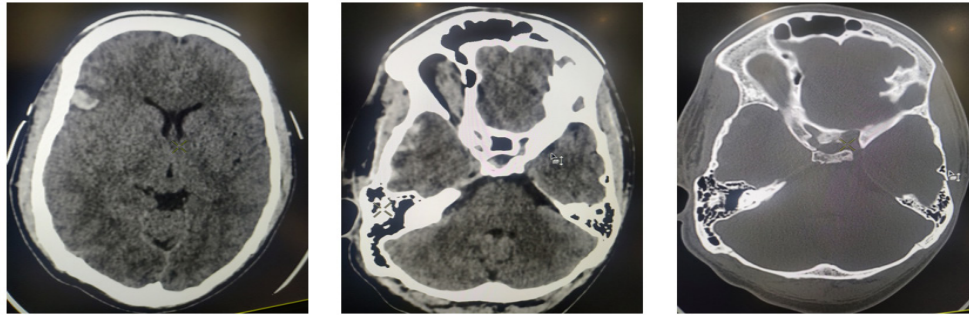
CT scan (Head) at Day 0: Right fronto-temporal contusion
